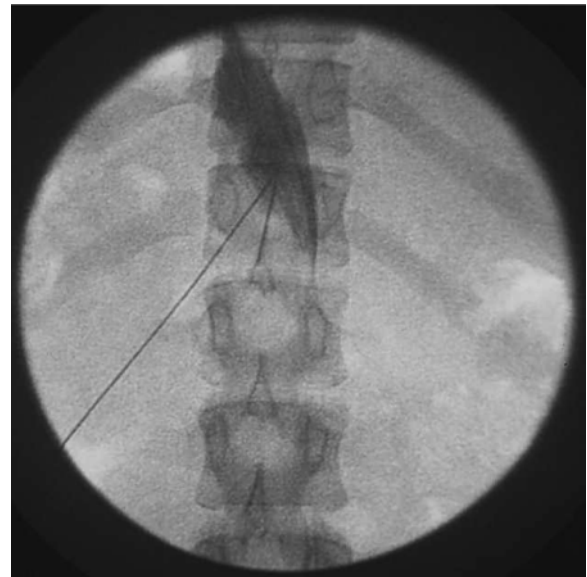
Antero-posterior radiograph showing dye in the midline at T12
